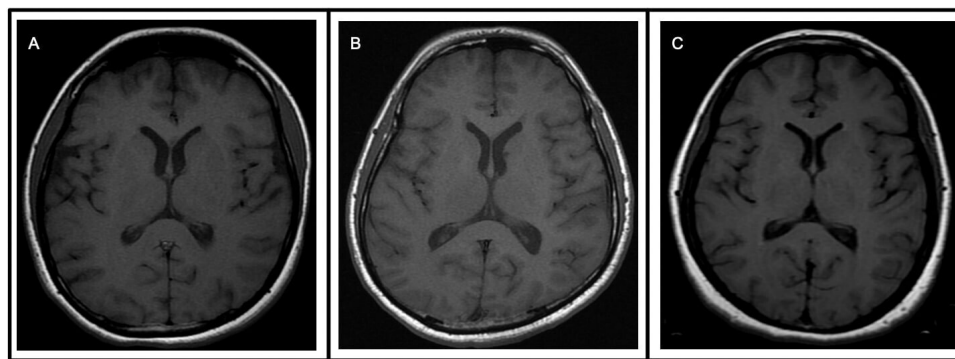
Normal MRI findings of patient 1 (A), patient 4 (B), patient 5 (C).
